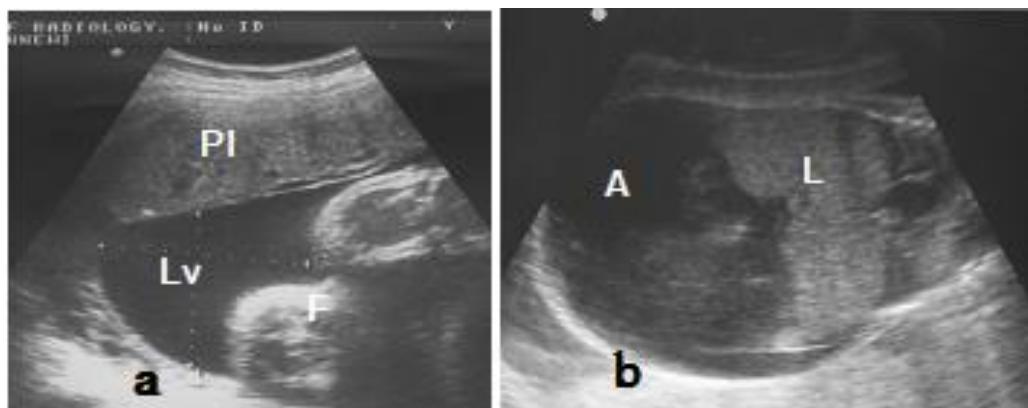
Sonogram showing, a. A pocket of amniotic fluid with how to measure liquor volume (Lv), placenta (Pl), and foetal parts (F). b. Ascites (A) or fluid within foetal abdomen and enlarge liver (L) in another patient with hydrops foetalis.
